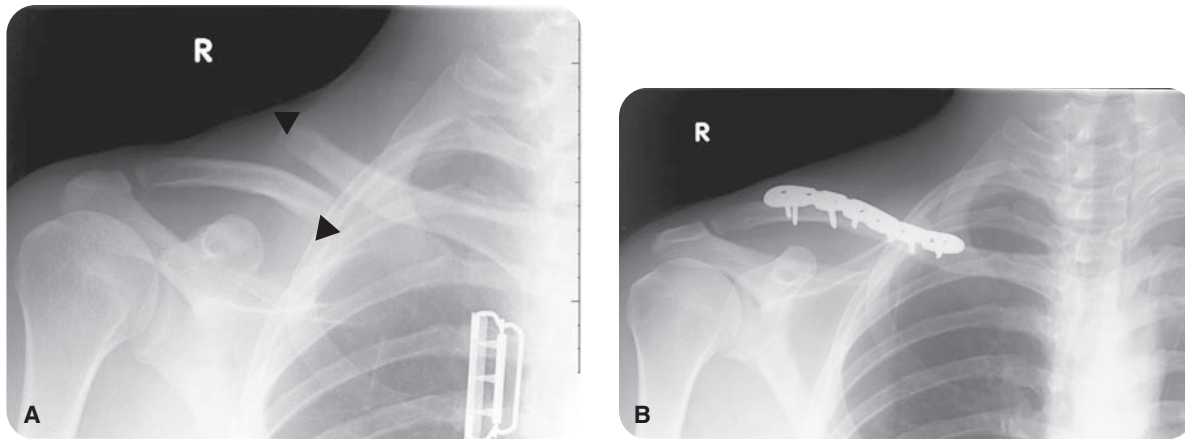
Neer type II. (A) Anteroposterior radiograph of the right clavicle, demonstrating an acute fracture of the middle of the clavicle with cephalad displacement of the proximal fracture fragment that overrides the distal fragment (*arrows*). However, the right acromioclavicular joint is intact. (B) A follow-up radiograph, demonstrating multiple fixation plates and screws from open reduction and internal fixation in the same patient.
